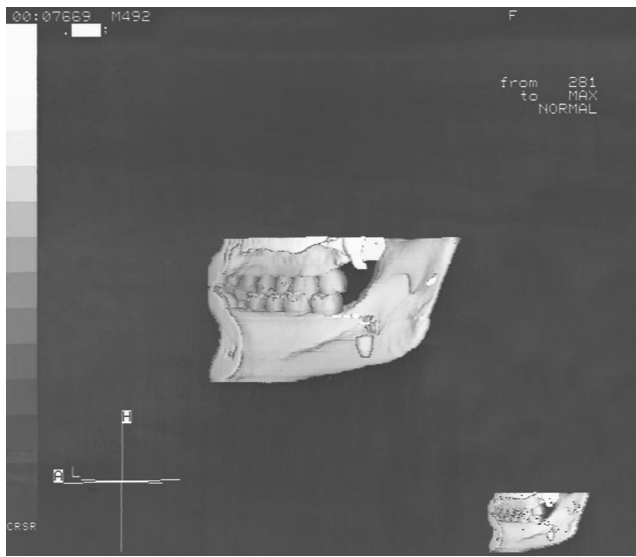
A 3-dimensional CT scan reconstruction of the medial aspect of the mandible showing the mylohyoid ridge and the mandibular foramen. Slightly superior to the displaced root an osseous defect (fenestration) is visible.
